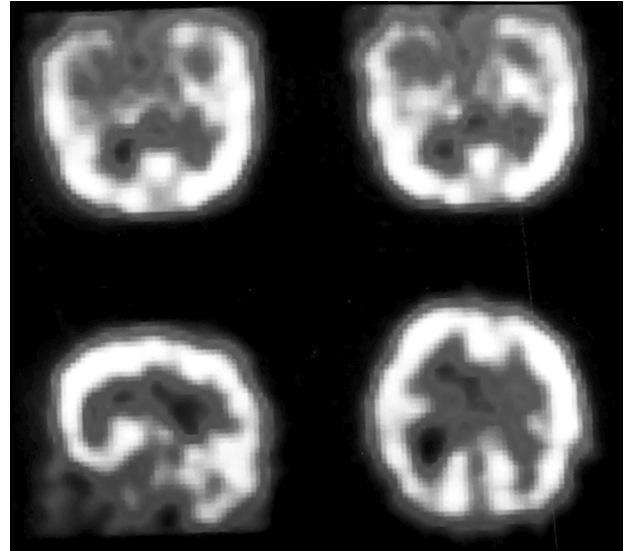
SPECT of Case 2. In the superior half two rebuilt cuts in the temporal axis. Hypoperfusion in the temporal lobe shows an area of moderate hypoperfusion in the medial area of the right temporal lobe. The image of the sagittal inferior axis to the left shows discrete hipoperfusion of the brain cortex and the image in the right inferior transversal axis shows morphological alteration of the brain cortex, the right hemisphere is bigger than the left one and more indirect of ventricular expansion.
